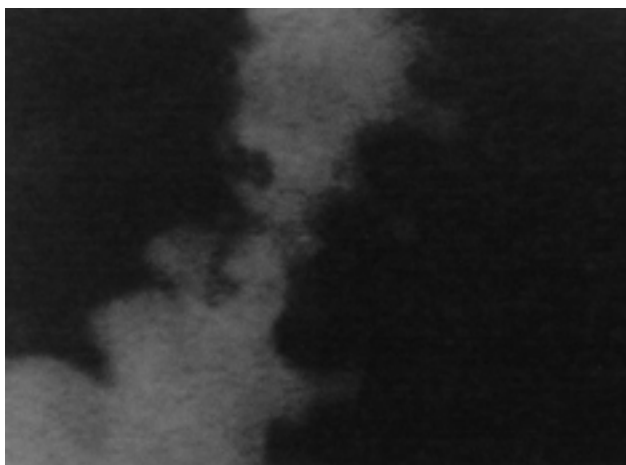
Radiographic appearance of stricture at the sigmoid-descending colon junction
